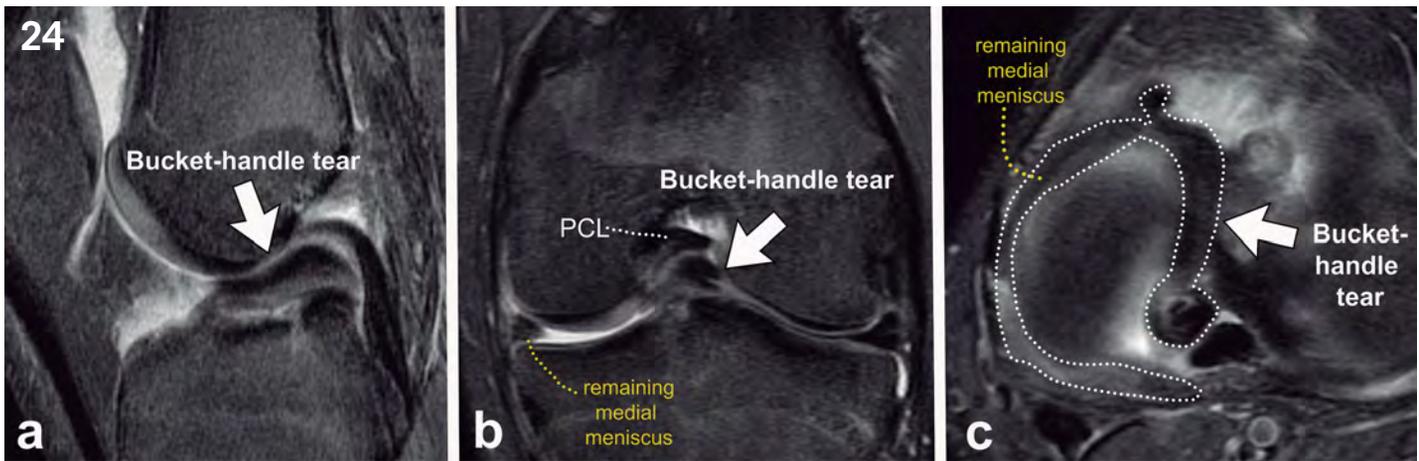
Meniscal bucket-handle tear. (a) Sagittal, (b) coronal and (c) axial T2-weighted fat-suppressed MR images of the knee. Complete vertical tear of the medial meniscus with displacement of the inner part of the meniscus to the intercondylar notch (arrows - bucket-handle tear). Note the typical “double-PCL sign” (in a), the remaining medial meniscus (in b and c) and the appearance of a bucket-handle that the displaced meniscal fragment creates with the remaining meniscus (in c). PCL: Posterior cruciate ligament.
